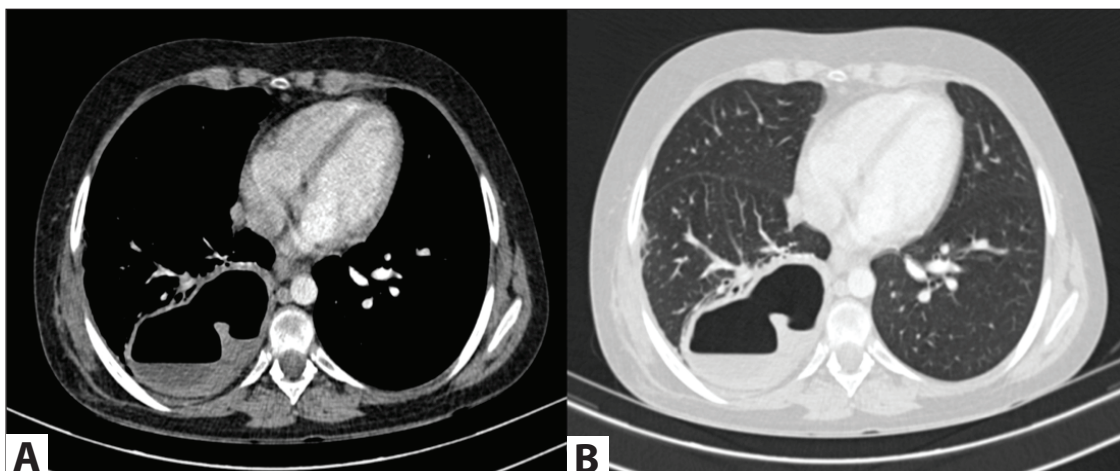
Axial chest CT on the mediastinum window (A) and parenchyma window (B).
